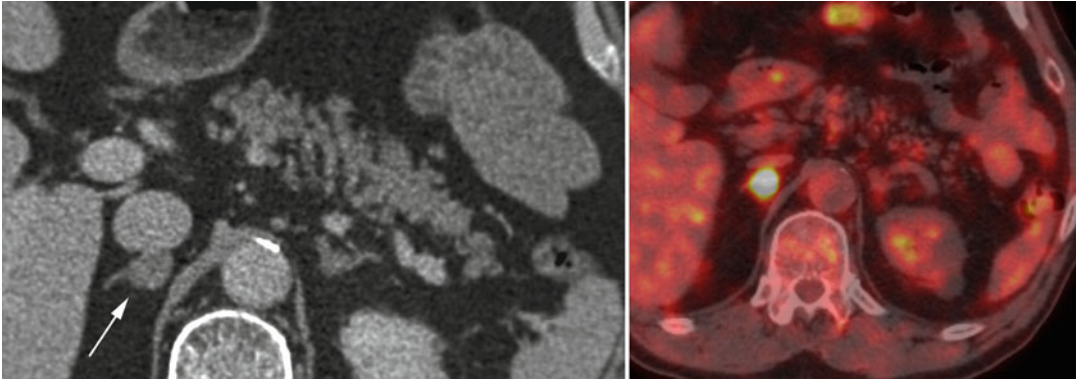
Indeterminate adrenal lesion (*arrow*). Axial CT and fused PET/CT images reveal a metabolically active right adrenal nodule. Because this was only potential
